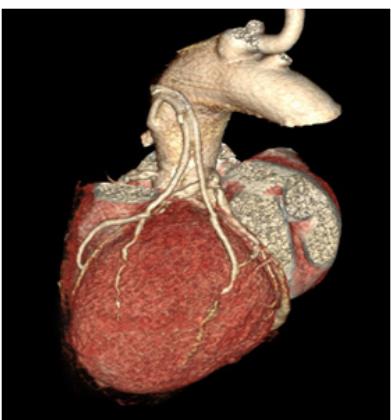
Volume rendering technique (VRT) CT coronary angiogram image showing good overview of bypass grafts.
